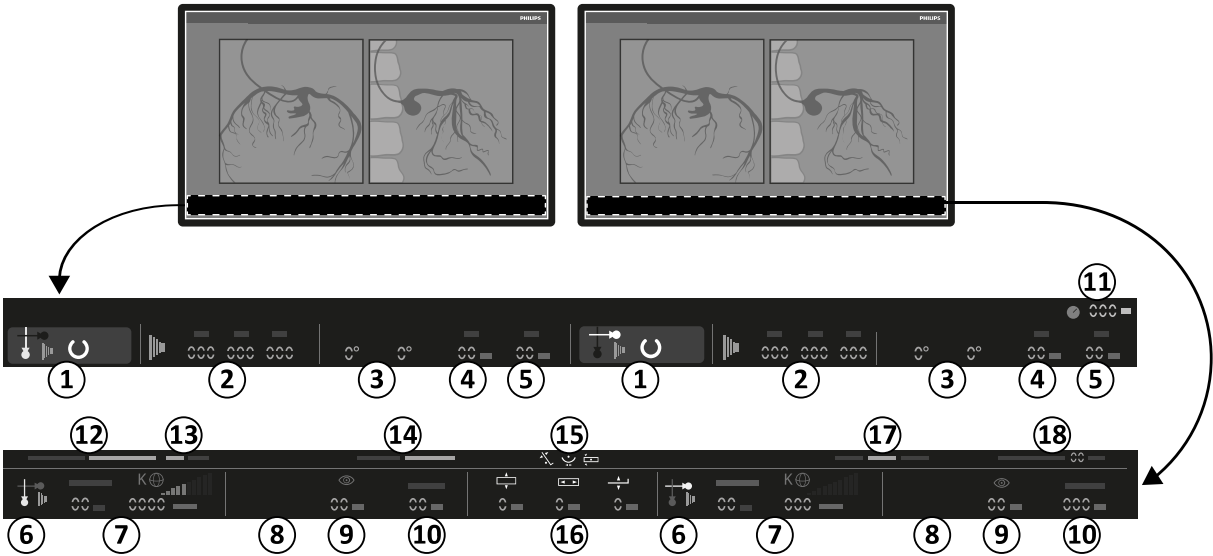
Status area in the examination room live X-ray window and reference window
